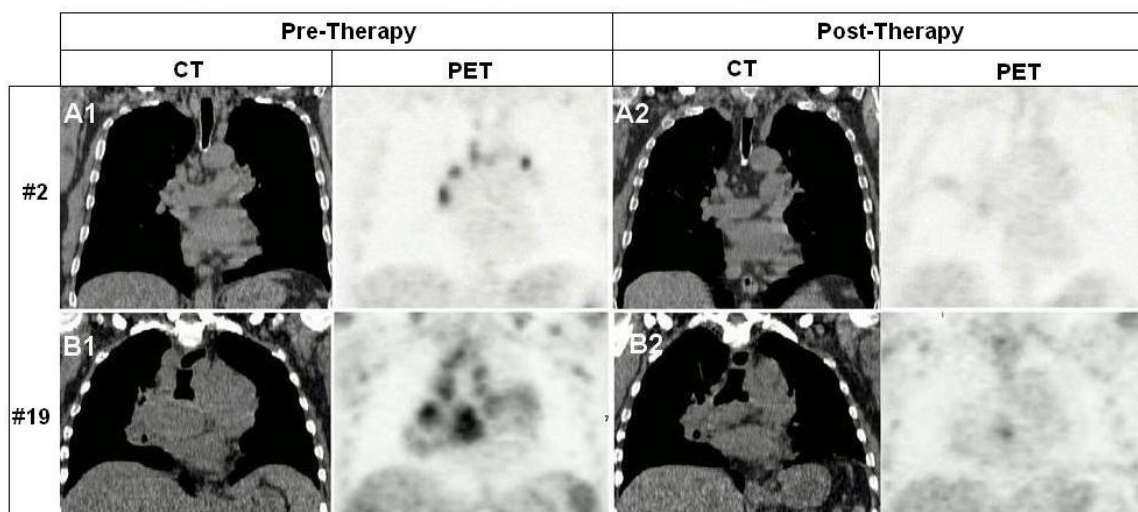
Visual Comparison of Change between PET and CT
